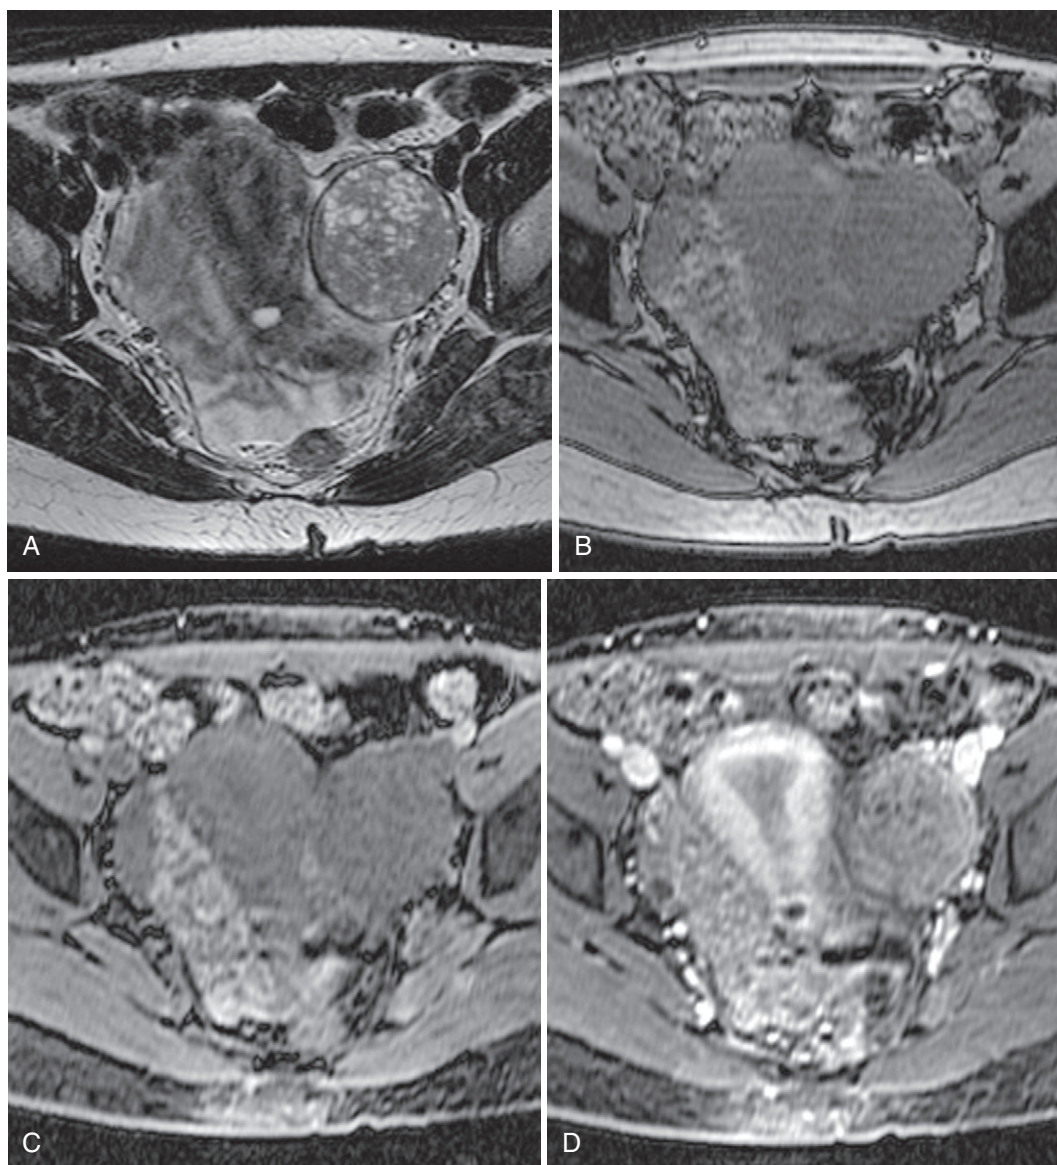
Granulosa cell tumor. A, In this case, the tumor is mostly solid with punctate hyperintense cystic foci on the axial T2-weighted image. The monotonous isointensity on the out-of-phase (B) and fat suppressed T1-weighted (C) images excludes hemorrhage. D, After intravenous gadolinium, moderate enhancement is noted.
